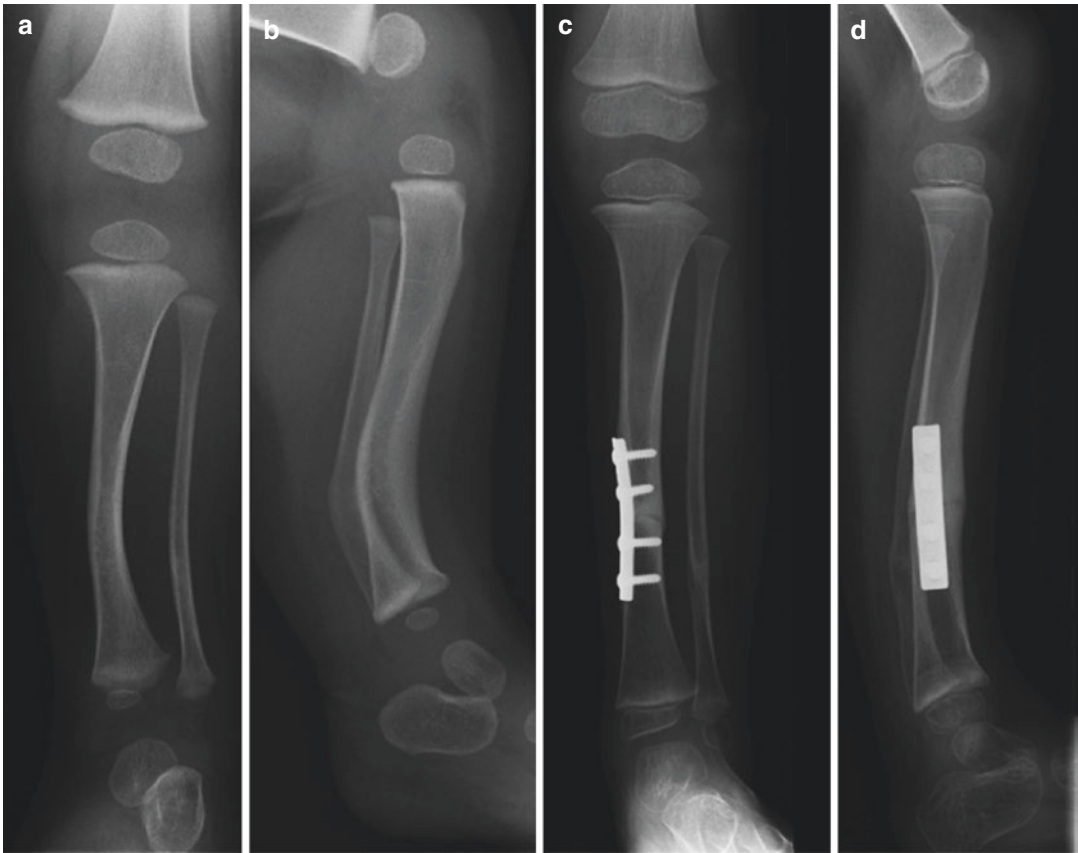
Congenital posteromedial bowing of the tibia and fibula of the left lower leg. (a) Anteroposterior X-ray. (b) Lateral X-ray. (c) Anteroposterior X-ray after corrective osteotomy. (d) Lateral X-ray after corrective osteotomy
